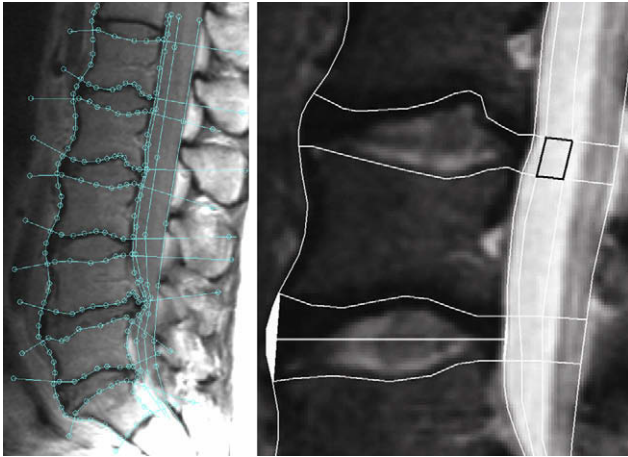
The left picture shows how the manual segmentation was performed using PD-weighted images: the first and second vertical lines follow the anterior and posterior longitudinal ligaments, the fifth vertical line follows ligamentum flavum, and the third and fourth lines provide cerebrospinal fluid (CSF) samples adjacent to the disc (this is confirmed in T2-weighted images). The horizontal lines follow the disc-vertebra interface. The picture on the right shows the areas of interest created: in the upper disc level, the mean disc signal and mean signal of adjacent CSF (black lines) are obtained. The lower disc level demonstrates the “bulging” areas and the remaining disc area (minus bulging) is divided by its diameter (the horizontal “mid-disc” line) to compute mean disc height [52].
